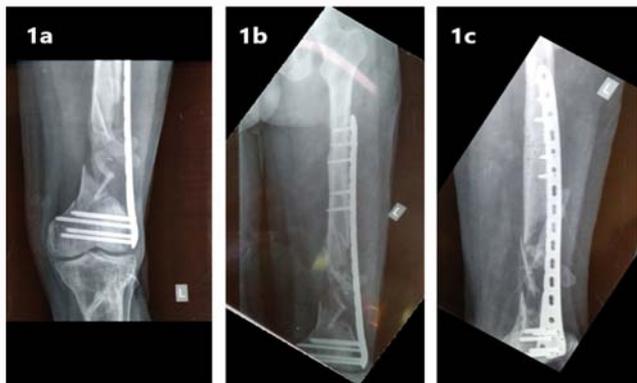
The preoperative radiographs showing the Anteroposterior (AP) view of the left knee (1a) and both the AP and lateral views of the left femur (1b and 1c). The radiographs clearly show that there is no evidence of union or presence of bridging callus at the fracture site at 6 months after the initial fixation. There is visible large bony gap seen at the distal femur, despite presence of multiple small bony fragments.
